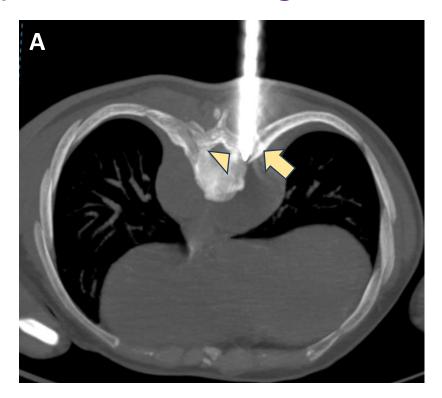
Image (A) Axial CT image demonstrates 14G Jamshidi needle in the groove between the vertebral pedicle (arrow head) and the head of the rib (arrow), entering the posterolateral edge of the vertebral body.
